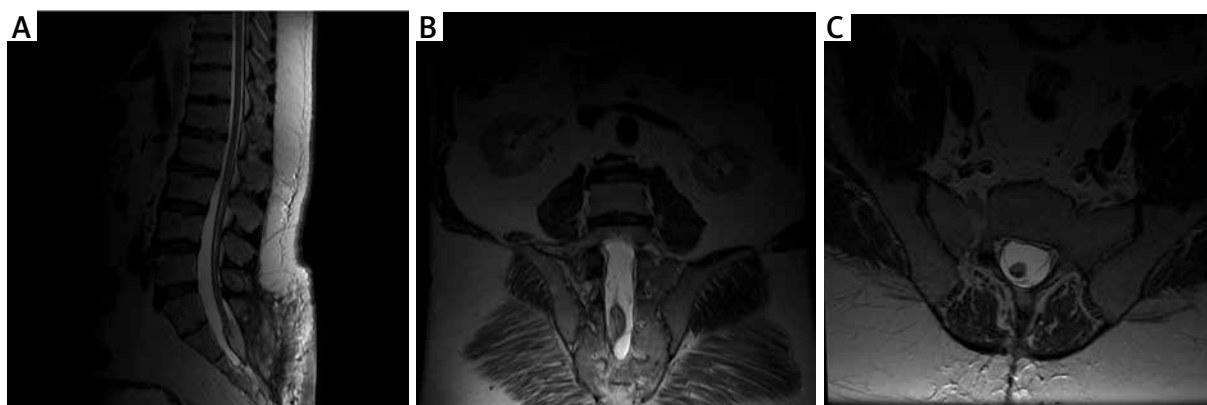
MRI scan at 12 months after surgery in 2 patients. A – MR T2 examination, postoperatively; visible postoperative wound, partially removed lipoma. B – MR T2 examination, postoperative coronal sections; remaining part of the adipoma is visible. C – MR T2 examination, postoperative axial sections
